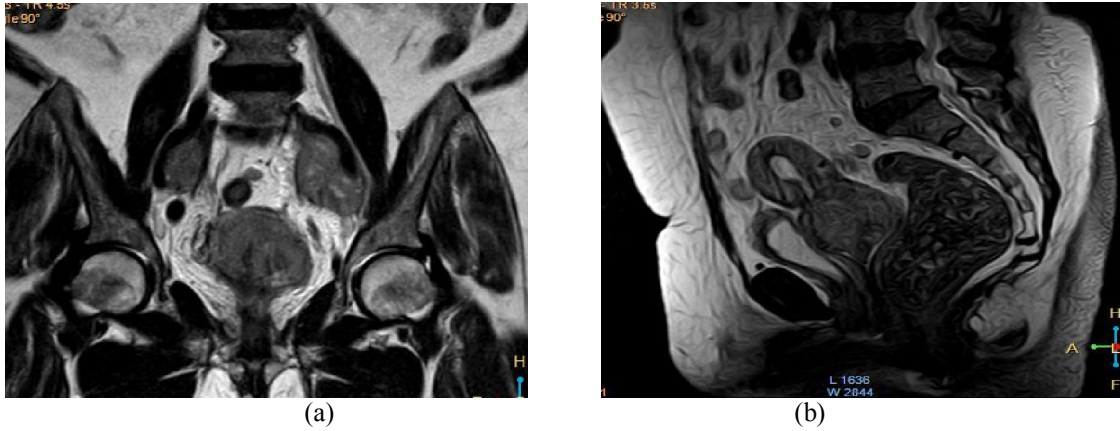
Pelvic MRI of 52 years old female: (a) Coronal T1W (b) Sagittal T2W images show diffuse cervical carcinoma with bilateral pelvic lymph nodes enlargement.
